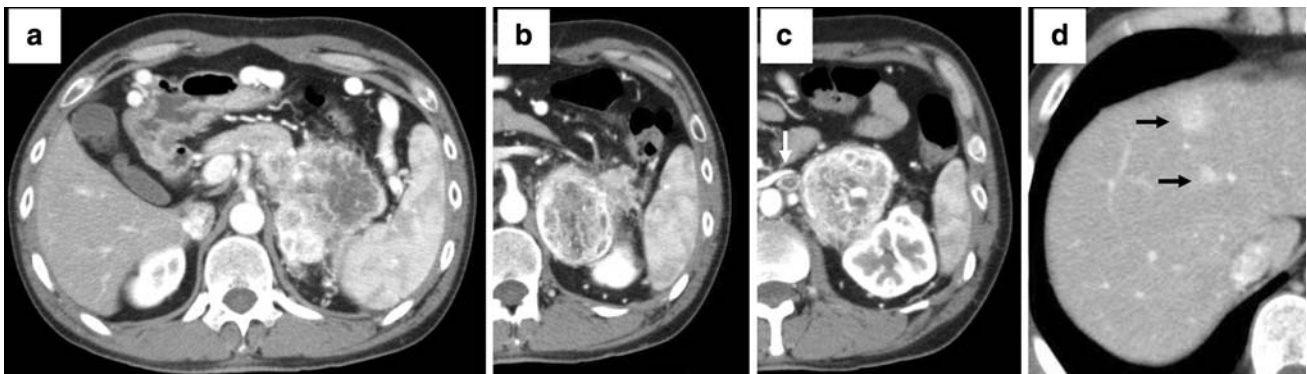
Abdominal CT scan shows hypervascular tumor, 10 × 7 cm in size, in the pancreatic body and tail (a). Metastatic lesions were present in the left adrenal gland (b), paraaortic lymph nodes (c arrow), and liver (d arrow)
